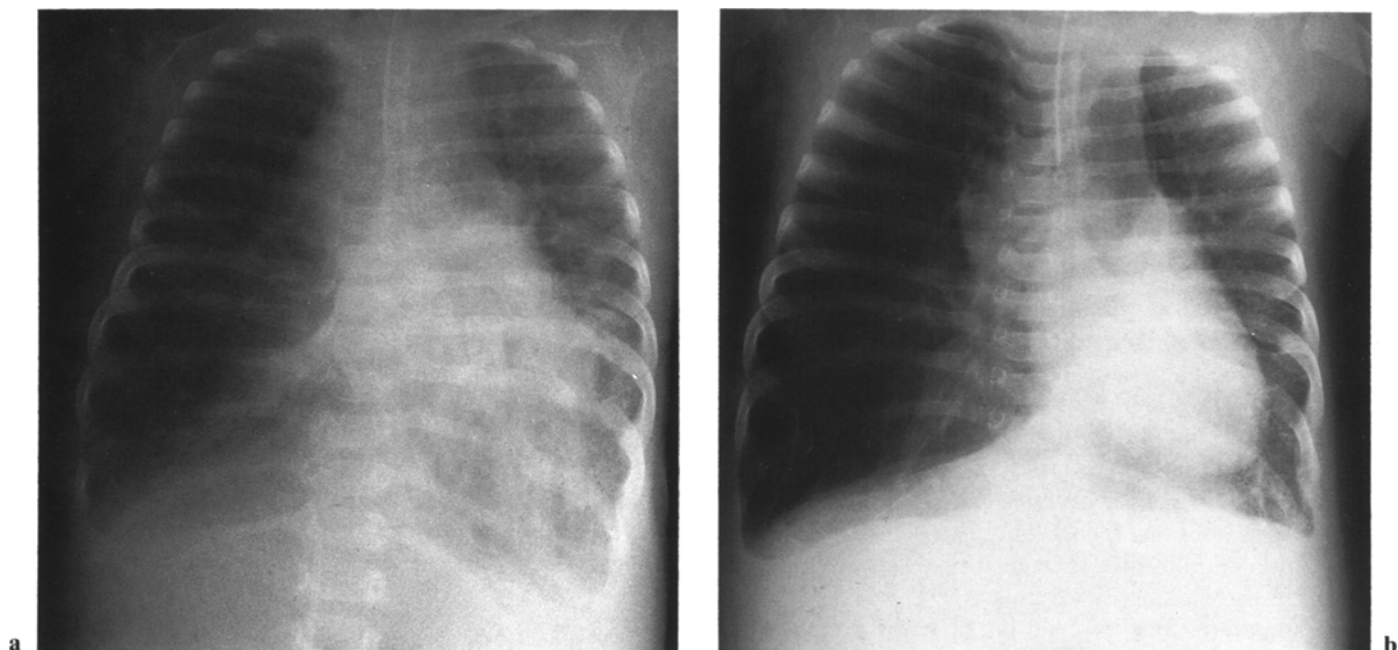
Chest X-rays before (a) and 9 days after (b) the start of NO inhalation. a Chest X-ray before NO inhalation shows marked increase in the hyperinflation of the lungs and infiltrates in the lower lung fields. b Chest X-ray 9 days after NO inhalation shows disappearance of the infiltrates and some improvement of the hyperinflation. The herniated right lung anterior to the heart and aorta, which developed about 1 month after admission, is observed
